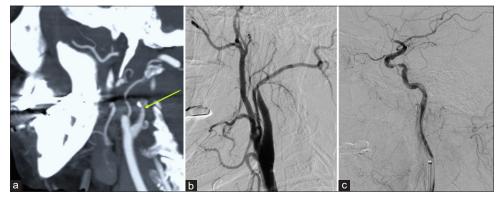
Imaging patterns of proximal ICA occlusion (a) flame shaped occlusion in CT angiography, (b) flame shaped occlusion in corresponding DSA (c) pseudo occlusion demonstrated after microcatheter injection. CT = computed tomography, DSA = digital subtraction angiography, ICA = internal carotid artery
